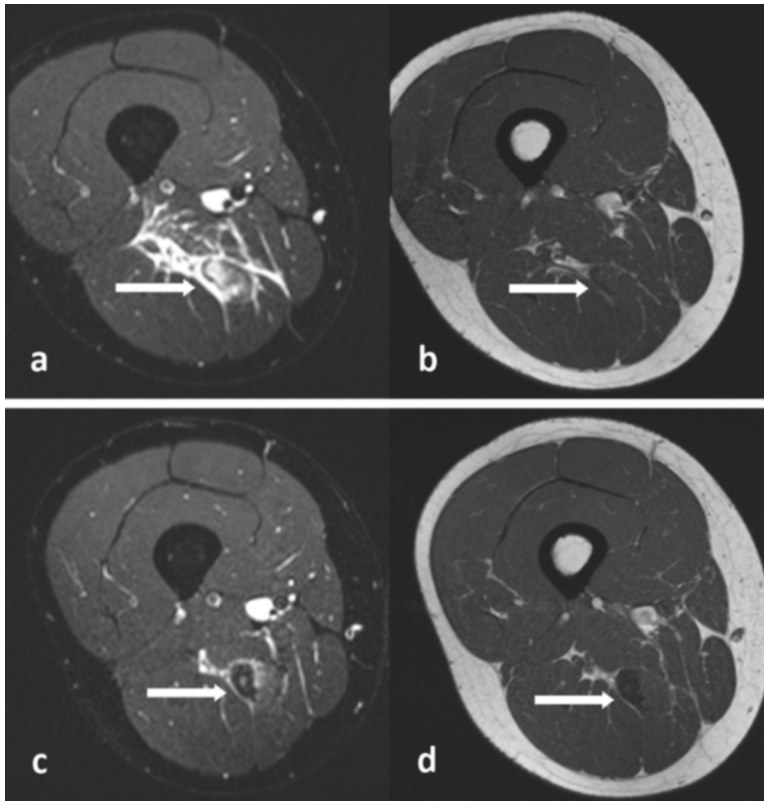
a and b) Images of the initial injury. The short- tau inversion recovery (STIR) image (a) shows increased signal intensity at the musculotendinous junction of the semimembranosus muscle (arrow). c and d) Images at return to play 50 days after the initial injury. Both STIR (c) and T1-weighted (d) images showing an extensive area of low signal intensity, indicating fibrous tissue formation (arrow). The fluid sensitive STIR image (c) shows a halo of increased signal intensity around the area of low signal.
